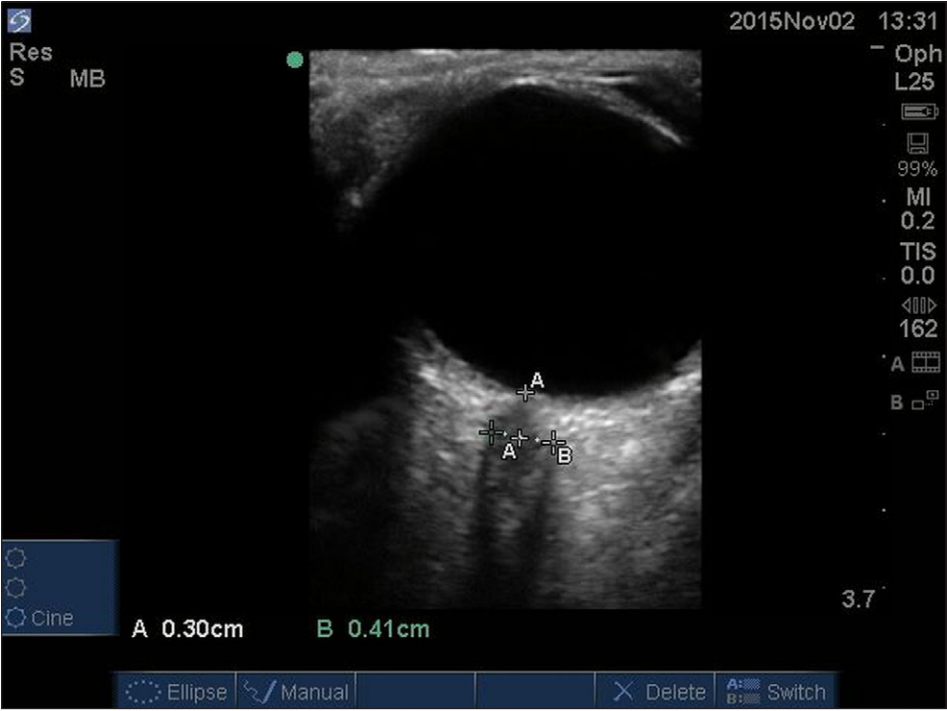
Sonographic image of the optical nerve sheath diameter measured 3 mm behind the retina
